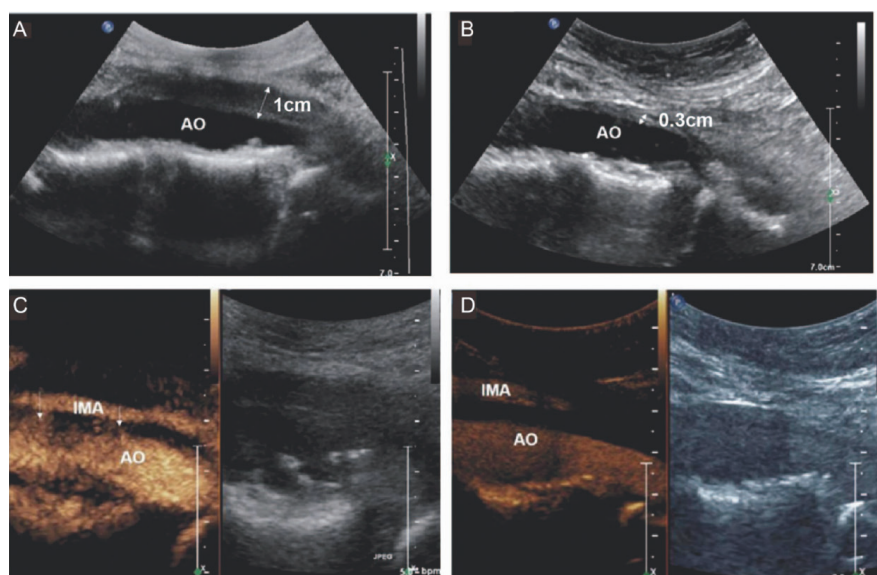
Ultrasound and contrast-enhanced images of retroperitoneal fibrosis.
